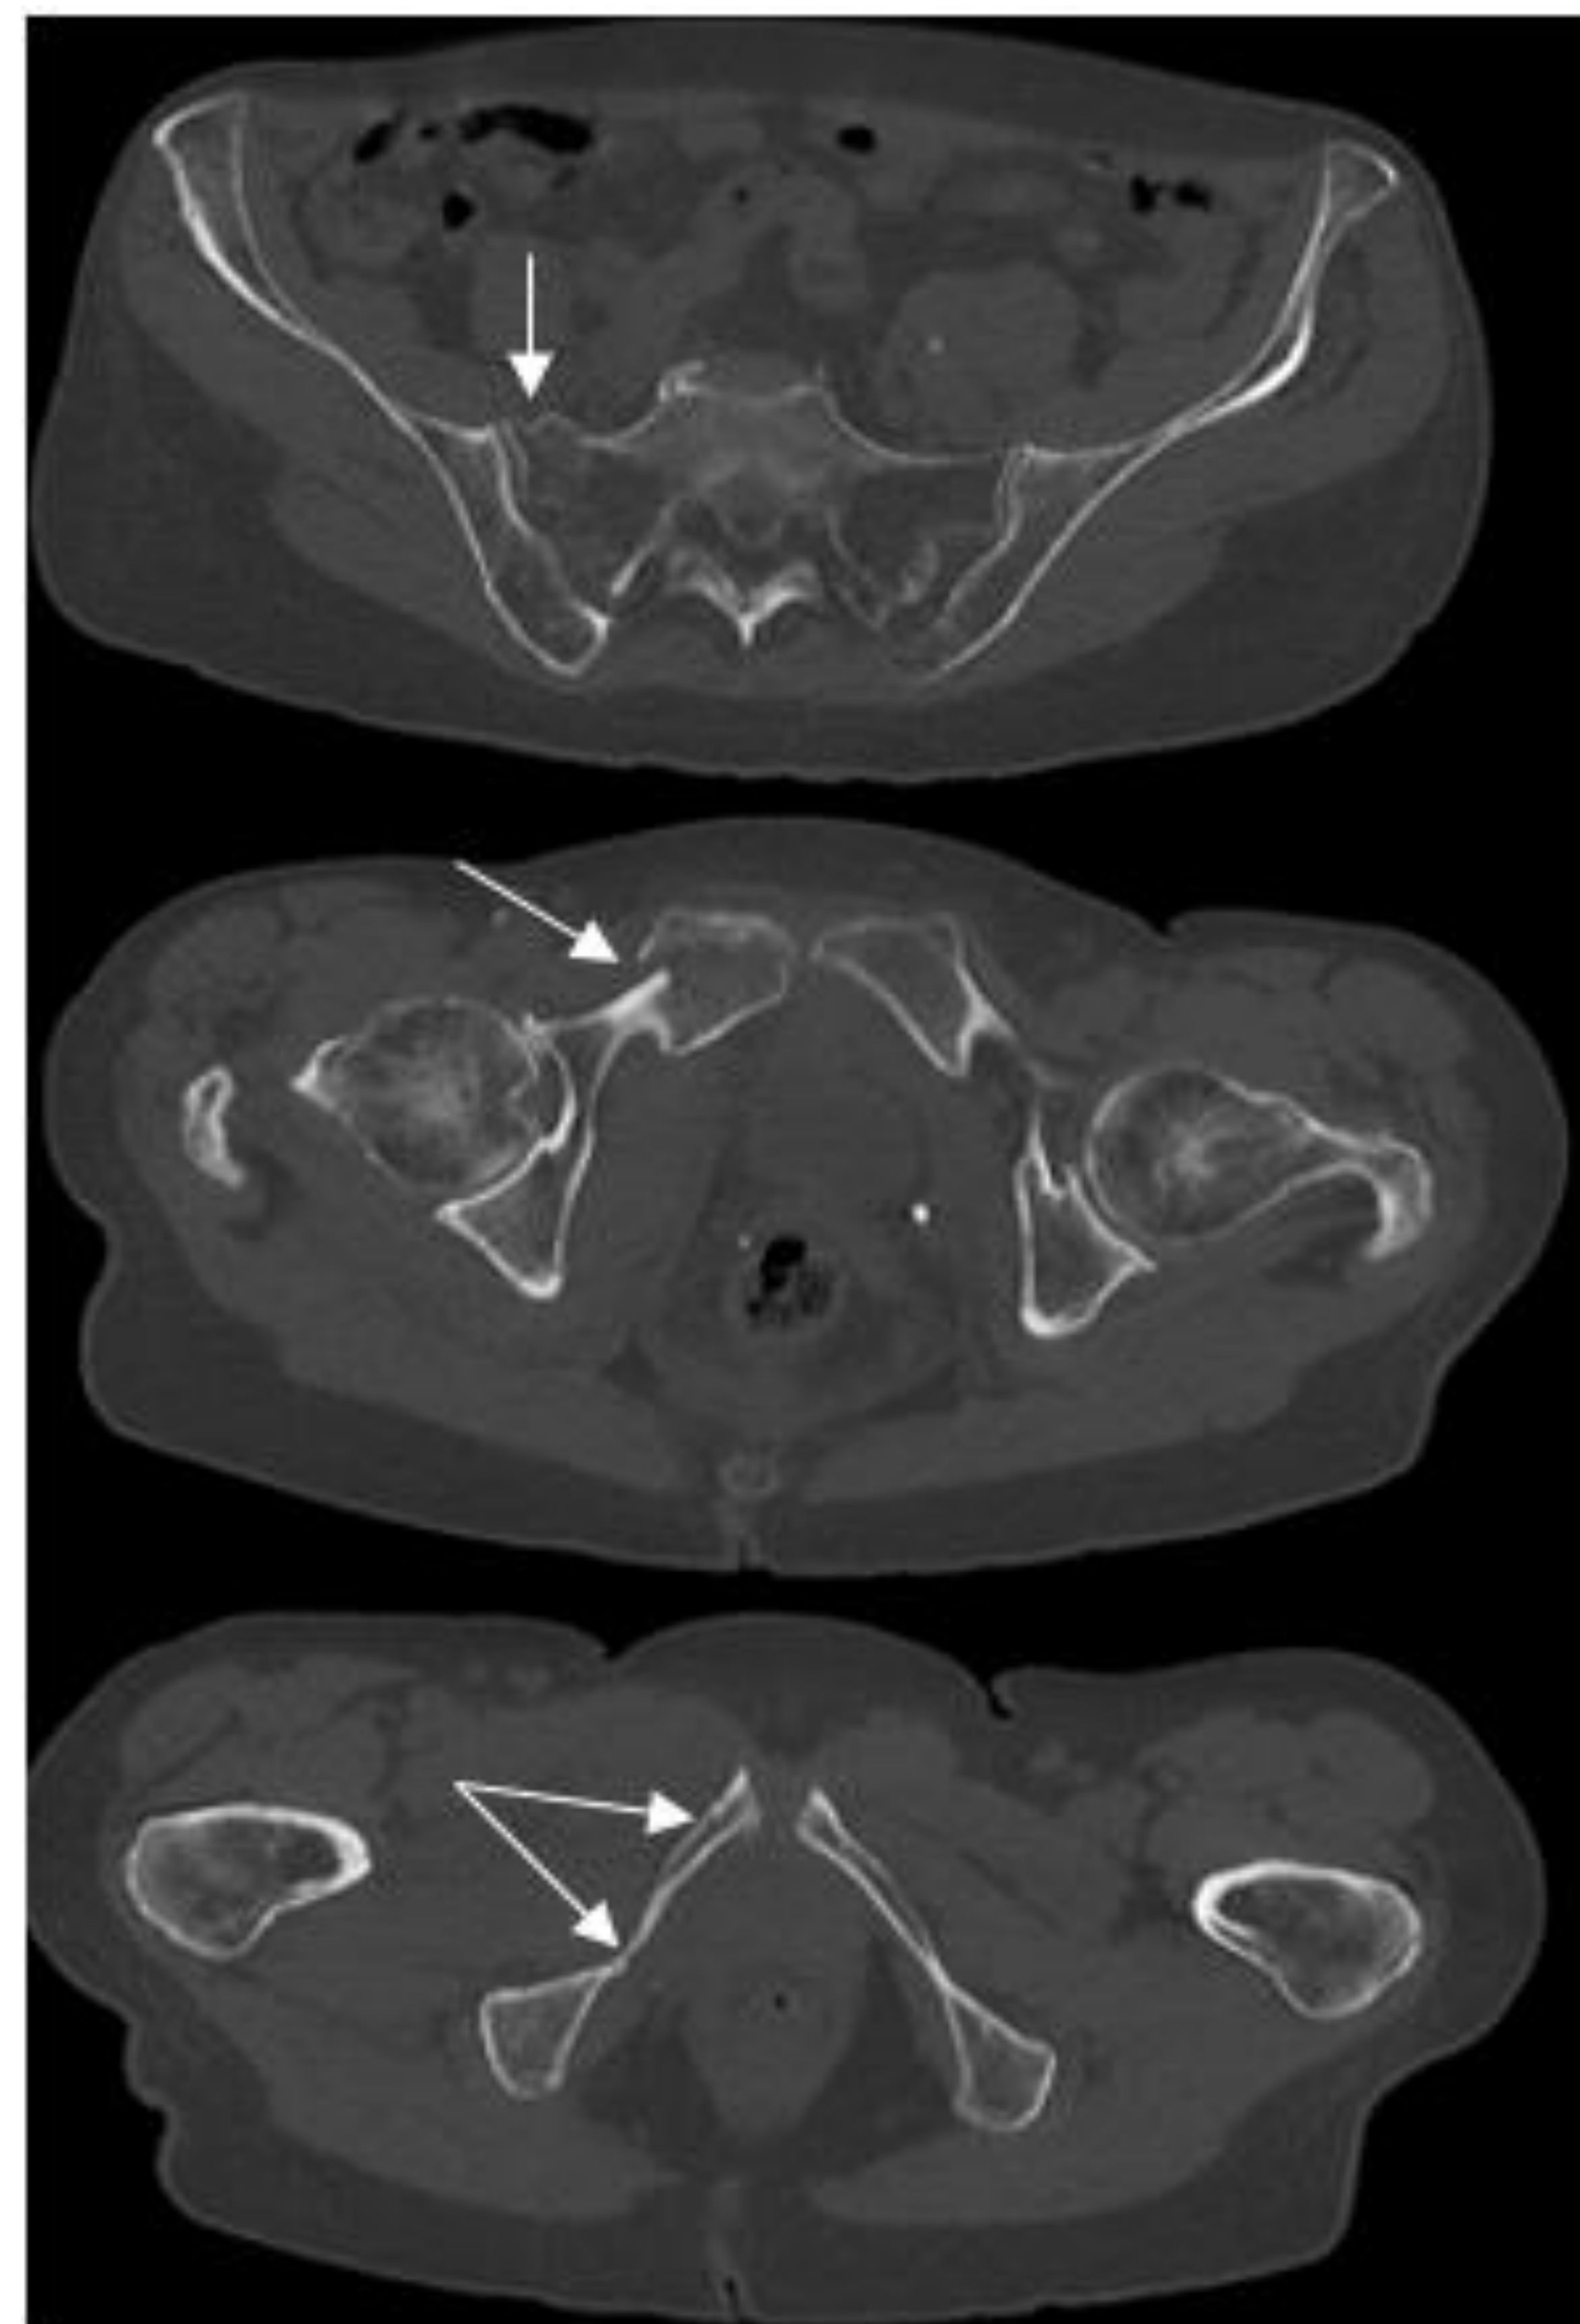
CT scan of LC1 fracture, female 82y.
